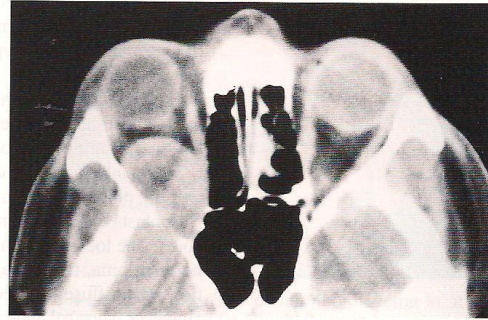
Axial computed tomography showing large circumscribed mass occupying most of posterior orbit and extending through the superior orbital fissure into the brain.
